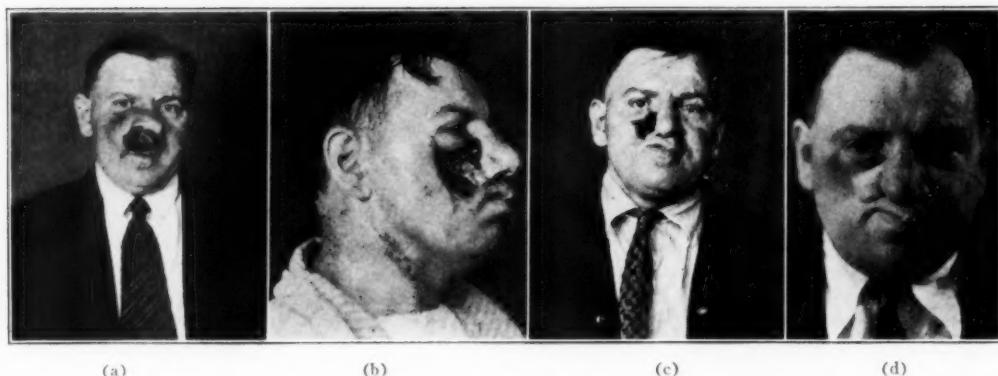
Sarcoma of the sinuses in a case of Paget's disease of the skull. The fleshy, easily bleeding tumor tissue is visible in the anterior nares. Both antra were involved by the neoplasm and the roentgenologic observation disclosed the presence of Paget's disease.
